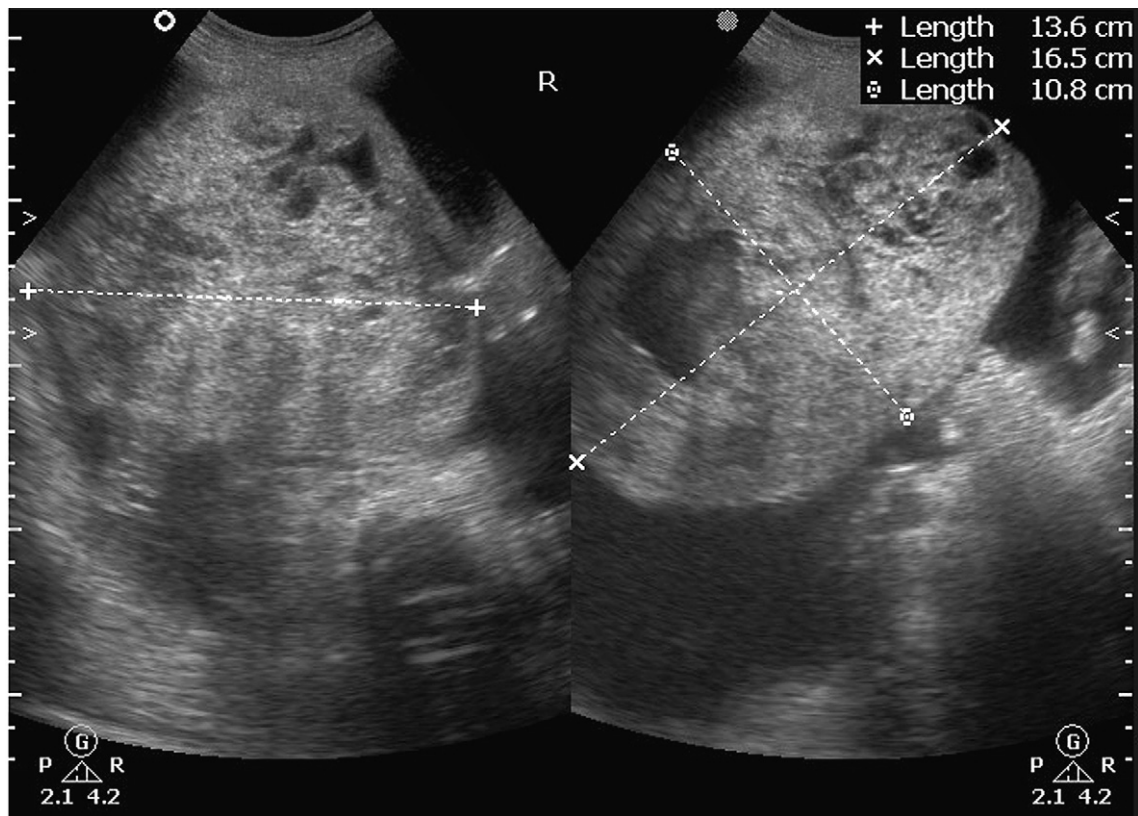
Abdominal ultrasonography shows a 16.5 cm \times 13.6 cm \times 10.8 cm solid mass in the right adnexa with focal cysts inside the tumor. A large volume of ascitic fluid is also visible.
